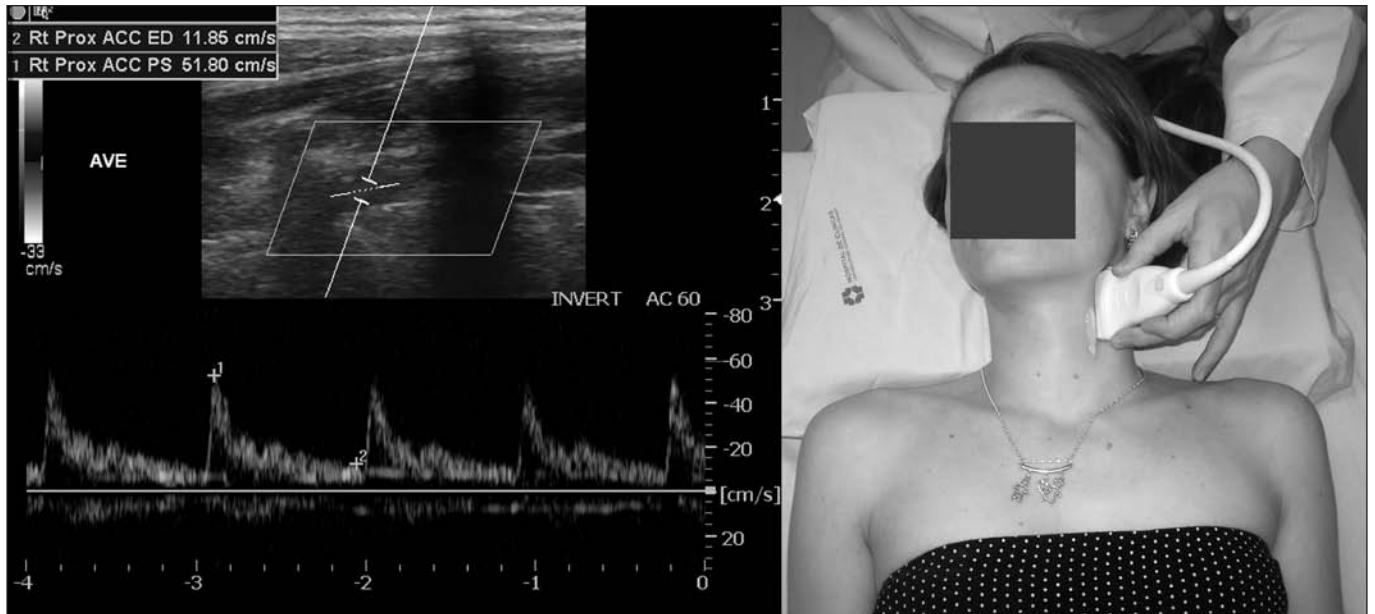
Arterial ultrasound: image of blood vessel and image of blood flow Doppler effect, and application of the method.
